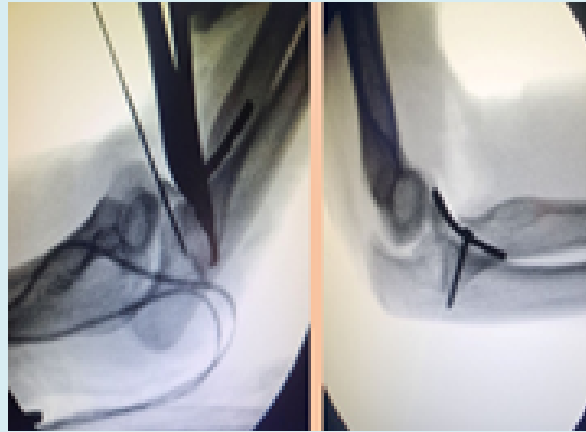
Intra-operative radiograph after reduction.
